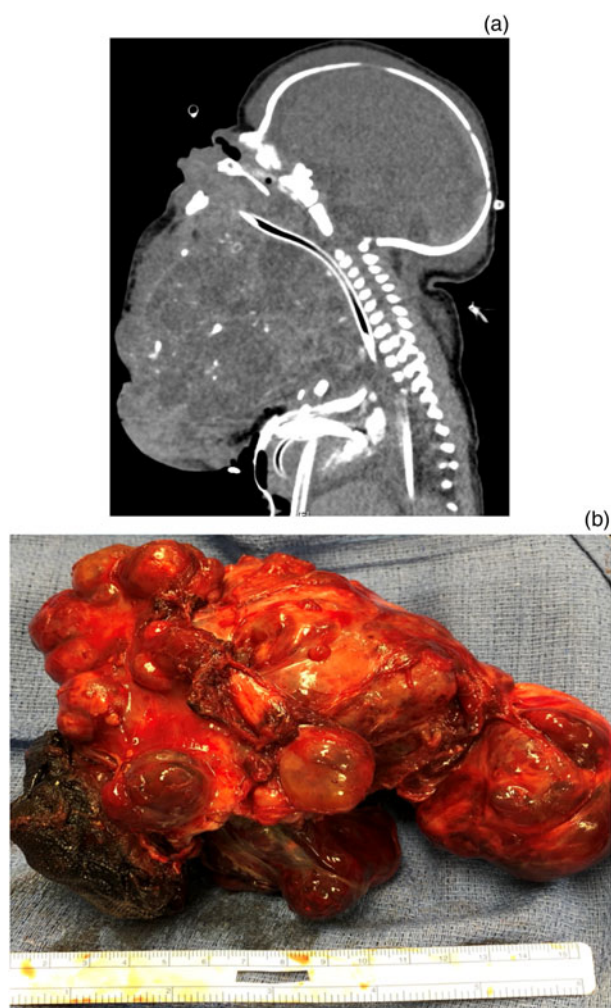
(a) Contrasted sagittal computed tomography scan on day of life 1, showing a complex midline cervicofacial mass measuring 15 × 14 × 11.3 cm. (b) Cervicofacial mass following resection, measuring 16.2 × 10.5 × 9.1 cm, with a weight of 585 g. Pathology revealed a grade 3 immature teratoma.
